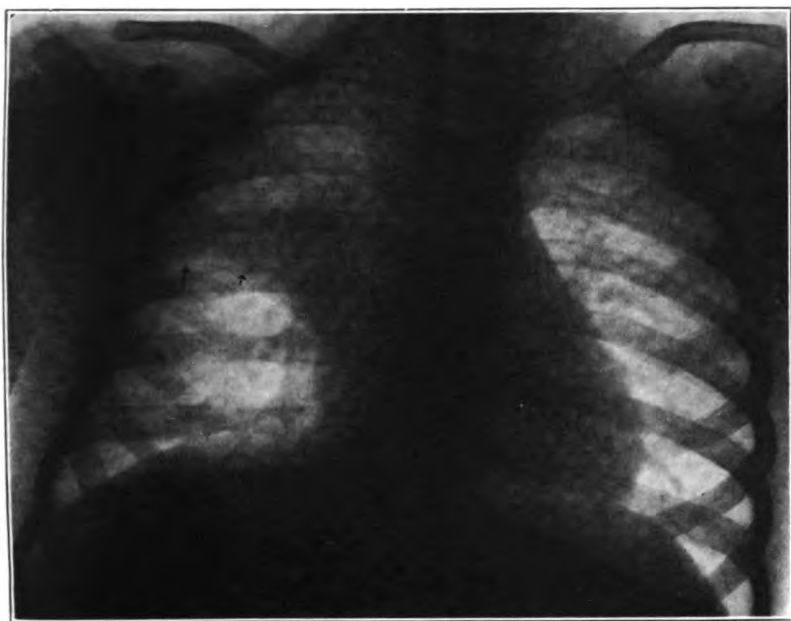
(Case 1). Radiograph of chest taken March 6, 1915. Enlarged bronchial lymph nodes surrounded by triangular infiltration at the root of the right lung. Thickened interlobar fissure indicated by arrow.
